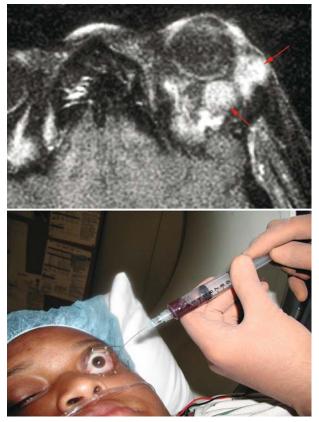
Evacuation of blood (red arrows on MRI) from orbit with a 21-gauge catheter.
